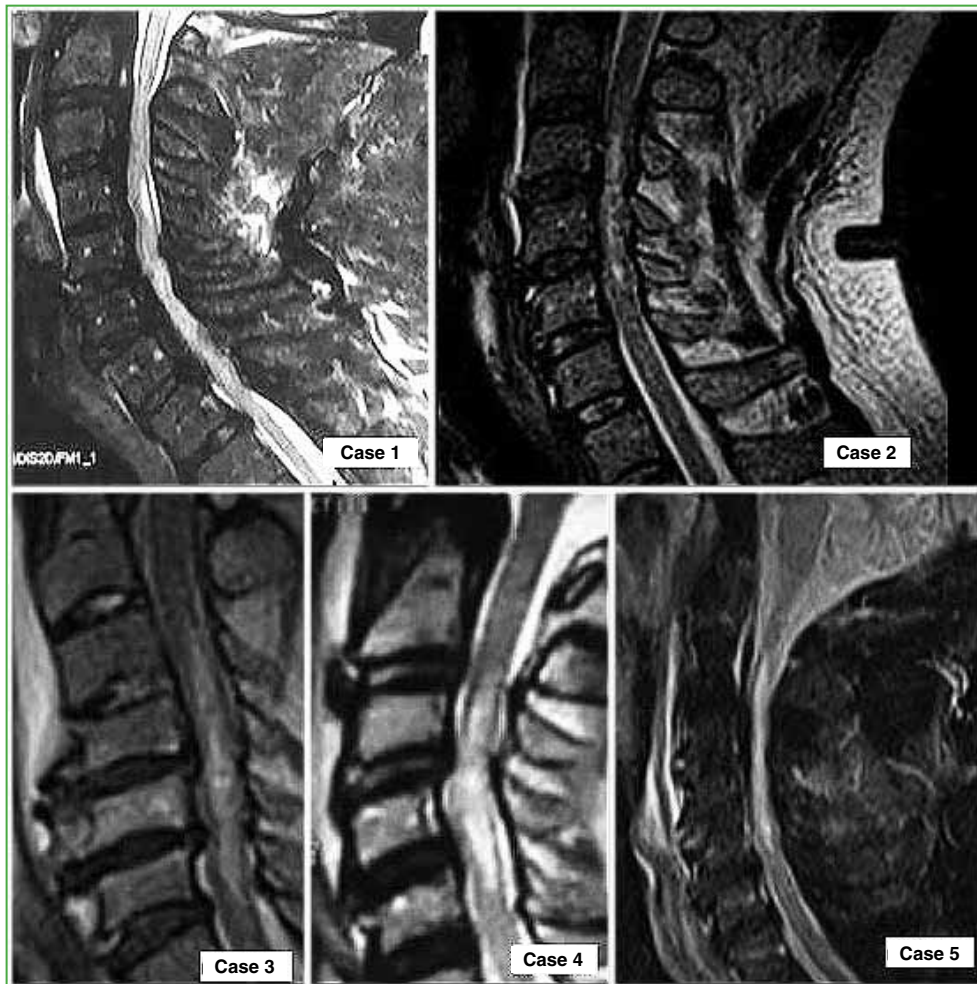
Initial MRI. Cases 1-5. Increased medullary signal in T2-weighted (Case 2) and STIR (Cases 1, 3, 4 and 5) sequences.
